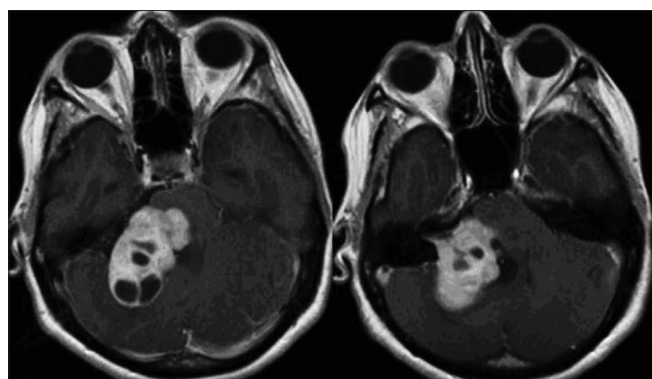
Preoperative magnetic resonance imaging scan
